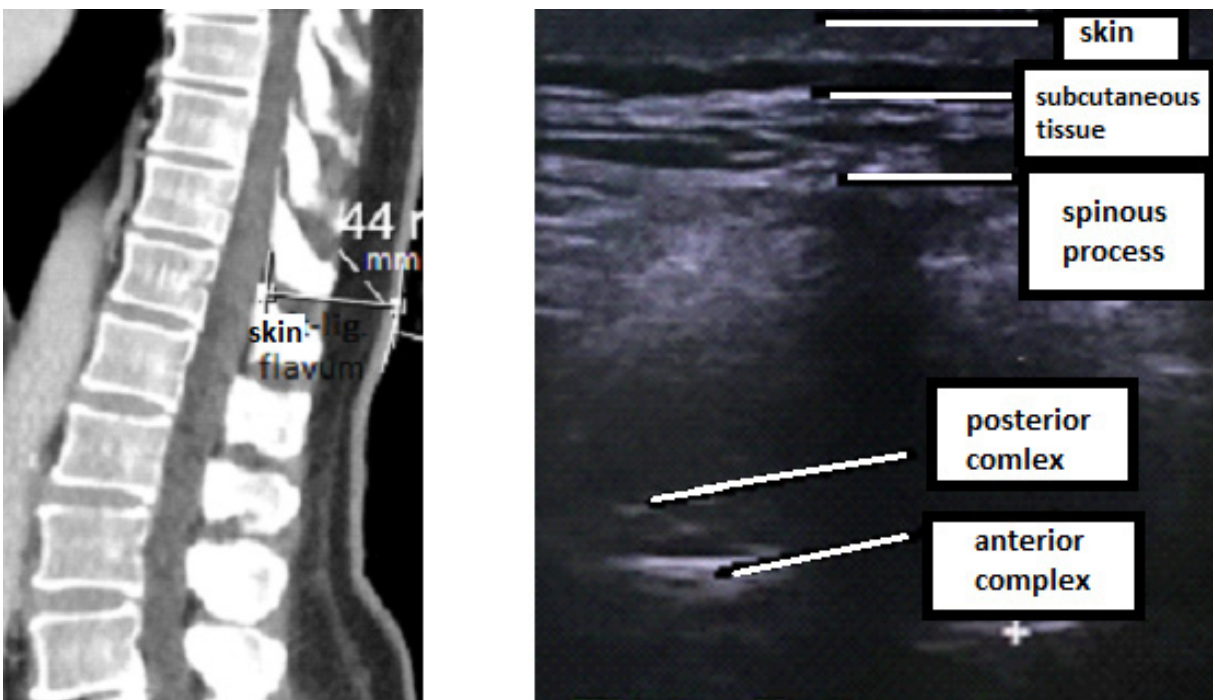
The CT measurement of skin-ligamentum flavum distance in the sagittal plane at the T11-12 level and the USG image of anatomical structures at the T11-12 level in the transverse median window acquired with the linear probe in the same patient
